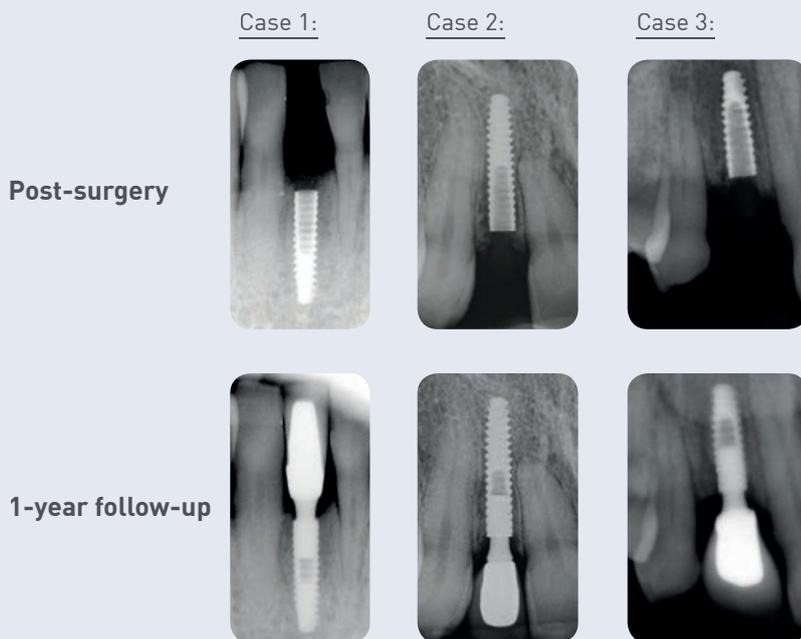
X-ray taken at 1-year postop
